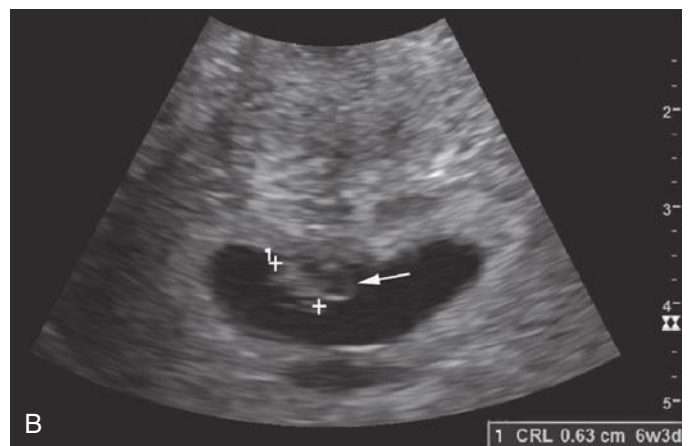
Transvaginal sonogram of an early intrauterine pregnancy and intrauterine device (IUD). The linear structure (*arrow*) seen in the lower uterine segment is an IUD. The relationship of the IUD and the gestational sac should be reported.
